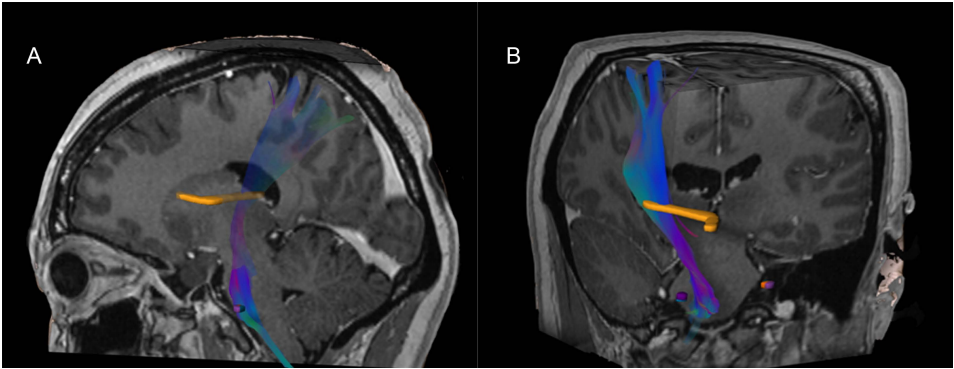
MRI tractography of the spinothalamic tract (blue tracts). (A), Sagittal view. (B), Coronal and oblique view. A partial view of the internal capsule is visualised in yellow colour.
